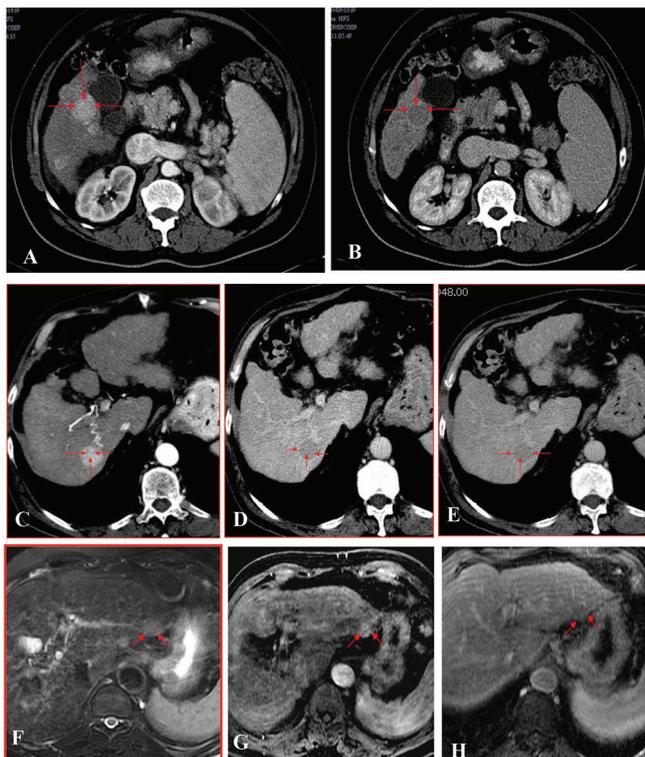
A. A 61 year old male with chronic liver disease showing Enhancing lesion in arterial phase in segment 5/6. B. - Delayed phase scan showing washout of contrast from the lesion. C. A 59 year old male with chronic liver disease. Small enhancing lesion in arterial phase in segment 6. D and E. (Portal venous and delayed phase respectively) showing washout of contrast from the lesion. F. MRI of 65 year old male with chronic liver disease with lesion size ranged 1 to 2 cm. - T2 (fat suppressed) axial image showing the bright lesion. G. Dynamic post-contrast scan in arterial phase showing enhancement of the lesion. H. Delayed phase – showing washout of contrast from the lesion.
